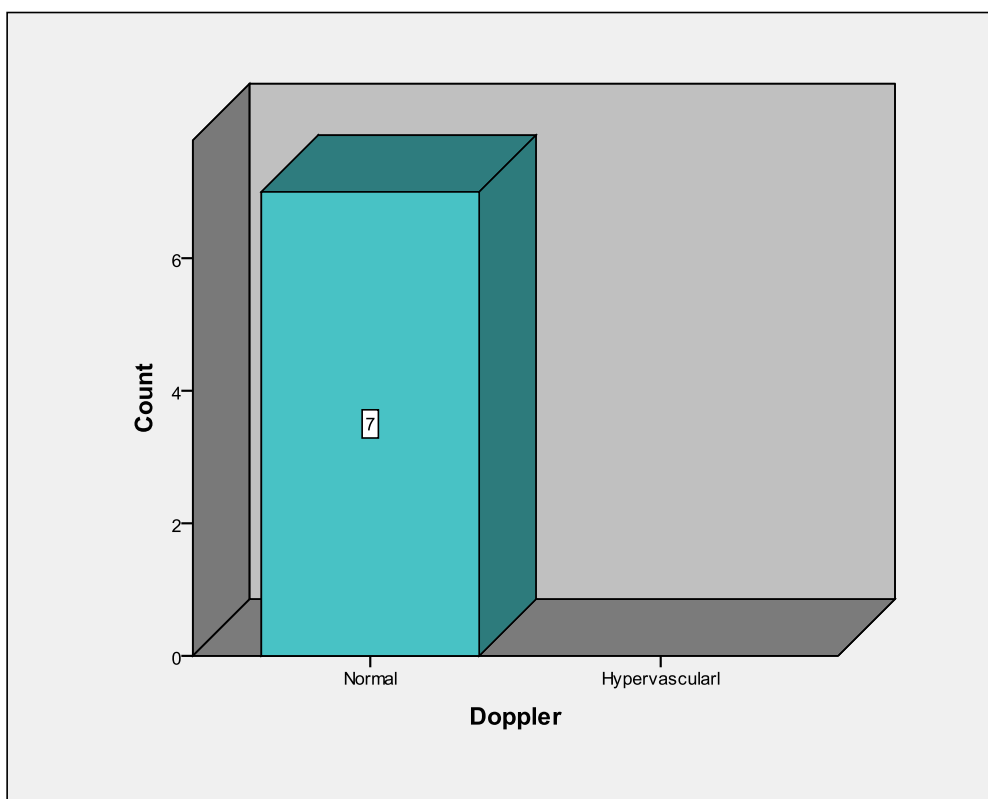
frequency distribution of Doppler
